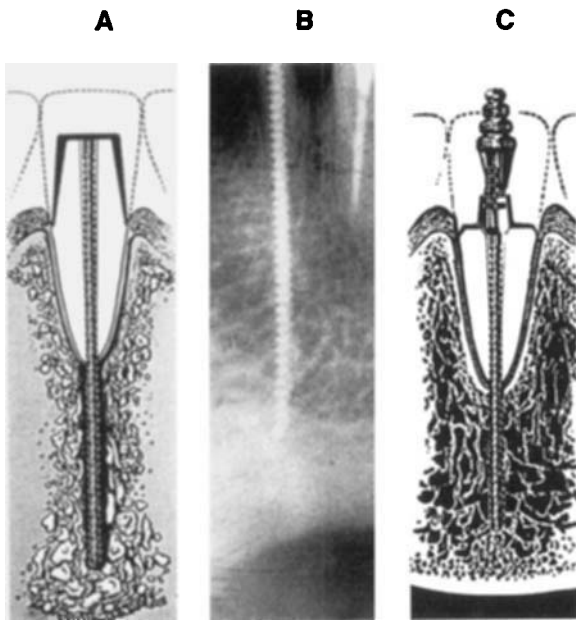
■ Seated stabilizer trimmed to support coronal tooth structure (A), radiograph of stabilizer seated to cortical plate (B), and post-core/stabilizer seated with hand wrench (C).
